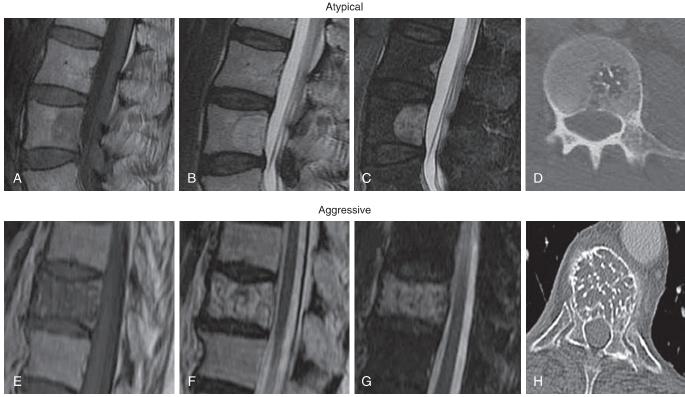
Atypical and aggressive vertebral body hemangiomas. (A–D) Atypical hemangiomas have reduced T1 signal (A) due to a relative paucity of intralesional fat and remain hyperintense on T2 (B) and T2 fat-saturated (C) sequences. Thickened vertical trabecula should be considered a key feature for the diagnosis (D). (E–H) Aggressive vertebral body hemangiomas show low T1 (E) and high T2 (F) and fat-saturated (G) signal as further evidence of replacement of marrow fat by vascular stroma. Aggressive vertebral body hemangiomas frequently have an atypical radiologic appearance on any imaging modality. Both MRI and CT should be obtained to look for the classic appearance (H) to help narrow the differential—however, ultimately biopsy may be needed.
